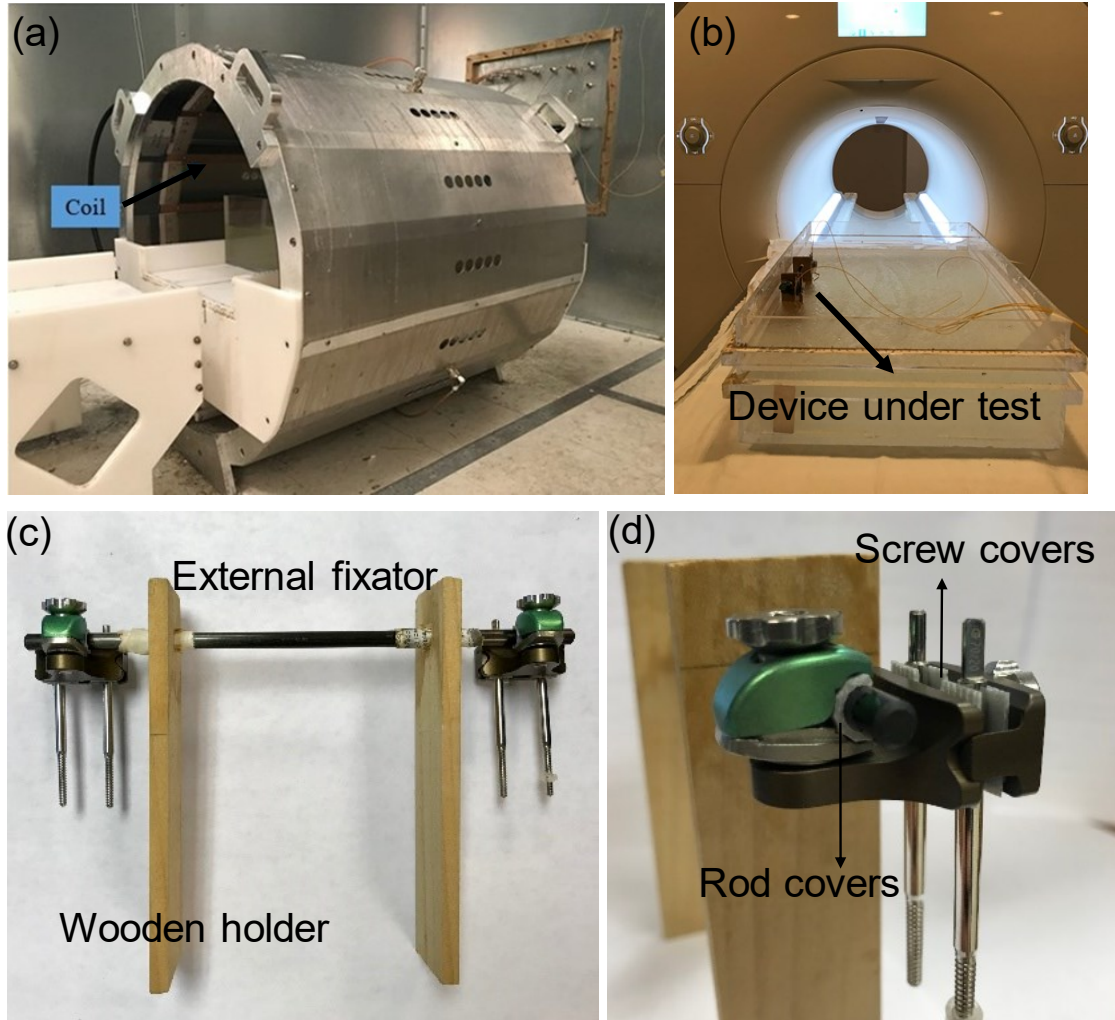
(a) A 1.5 T RF coil, (b) A 3 T MRI coil, (c) A commercial available external fixation device with wood holder, (d) Insulating materials applied on the rods (rod covers) and pins (pin covers).
